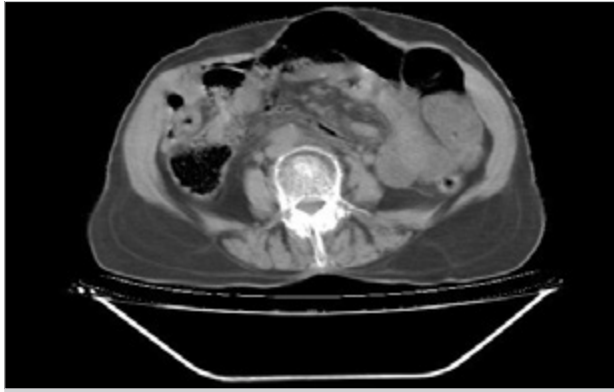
Free intraabdominal air on lower sections of abdominal computed tomography
